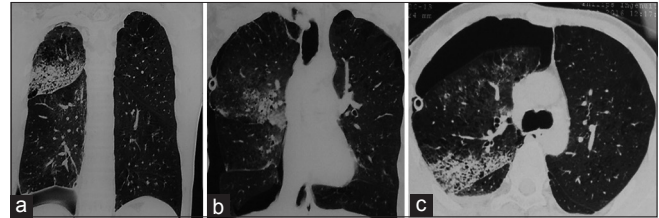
Computed tomography (CT) chest (a and b) coronal section showing evidence of edema in the right lung. CT chest (c) axial section showing pneumothorax with immediate intercostal tube tip along with ground glass opacities and interlobular septal thickening on the right side
